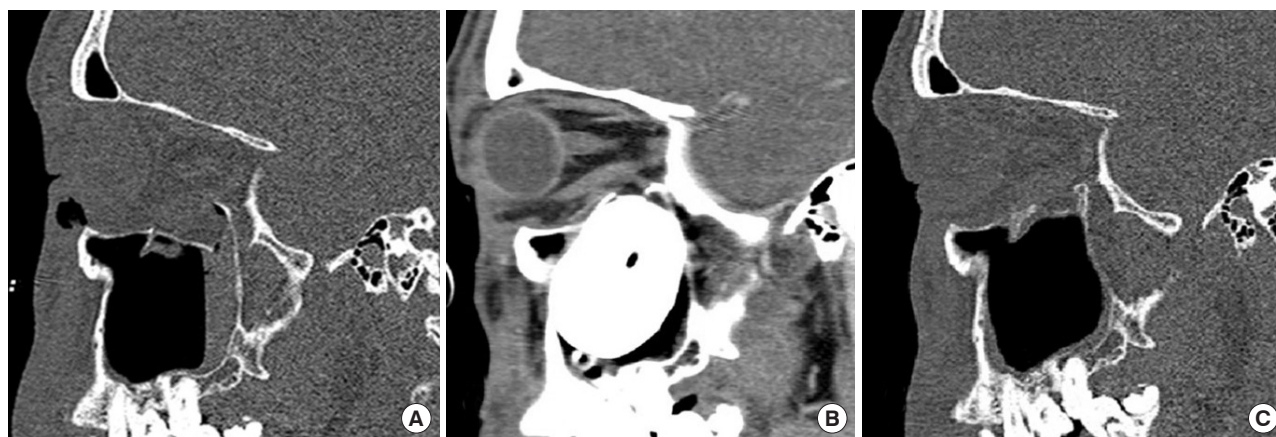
A 41-year-old man with a right inferior orbital wall fracture showing posterior ridge subsidence at 6-month follow-up after balloon removal. (A) Preoperative computed tomography (CT) scan. (B) Immediate postoperative CT scan demonstrating balloon support. (C) Six-month postoperative CT scan showing posterior ridge subsidence. The transnasal balloon was removed on postoperative day 7, and no enophthalmos was observed at the 6-month follow-up.
